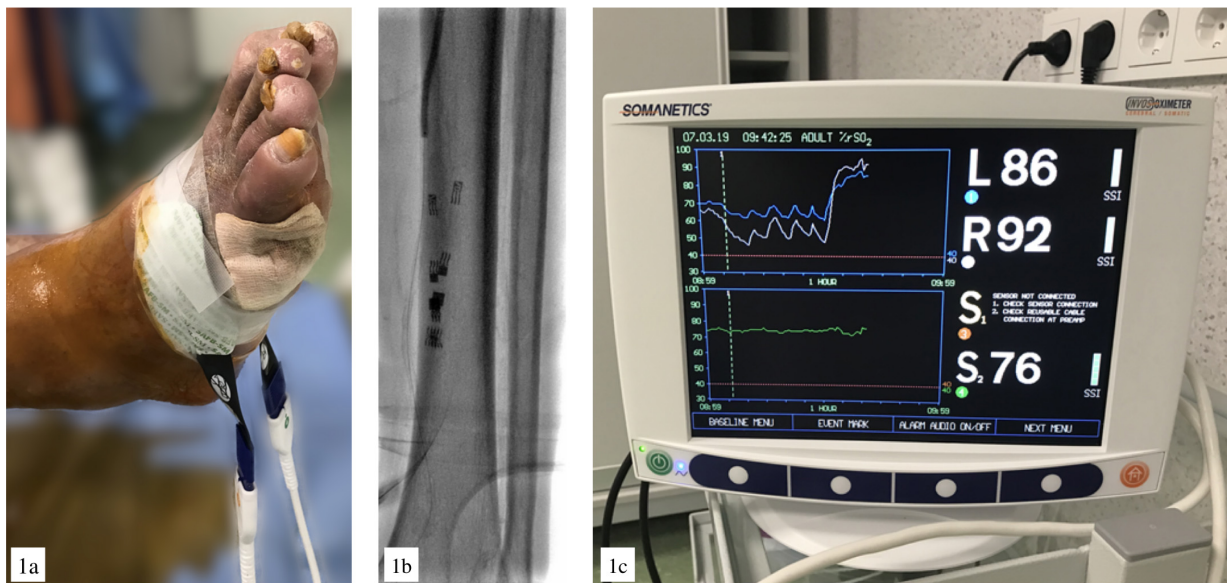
NIRS application during revascularization procedure. (a) Sensor placement near the wound. (b) X-ray view. (c) NIRS screen.
